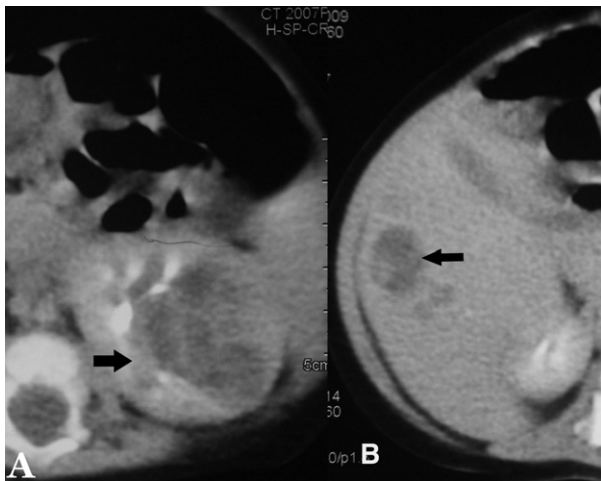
CT scan revealed a 38 × 35-mm heterogenous and hypoechoic mass in the middle of the left kidney (A, arrow) and 2 × 2-cm hyperechoic mass in liver segment 7 (B, arrow).
